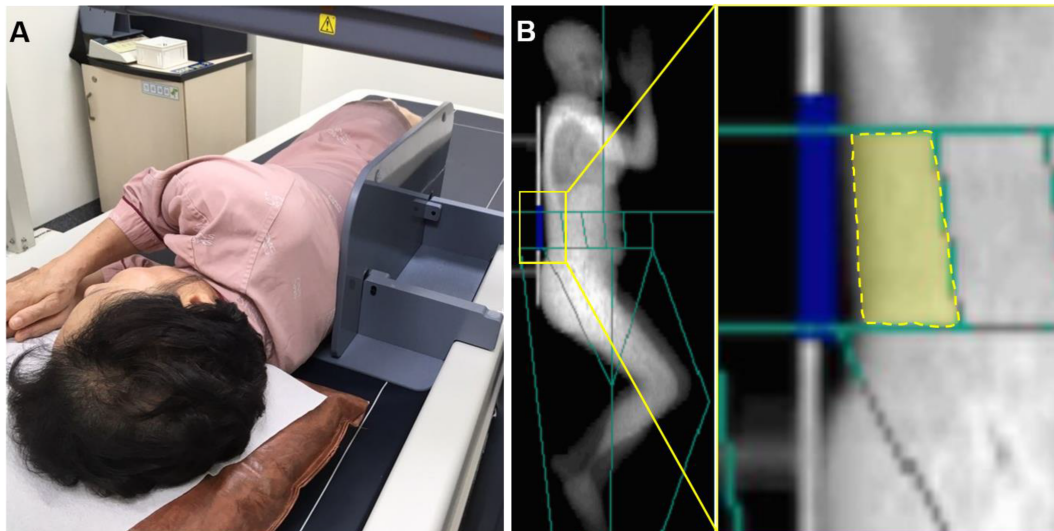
Measurement for body composition of lumbar paraspinal muscle by whole-body dual-energy X-ray absorptiometry in the lateral direction (lateral DXA): (A) lateral decubitus position with a lateral positioner over the back rail of the table, (B) defined region of interest (yellow dotted tetragon) to analyse the body composition.
